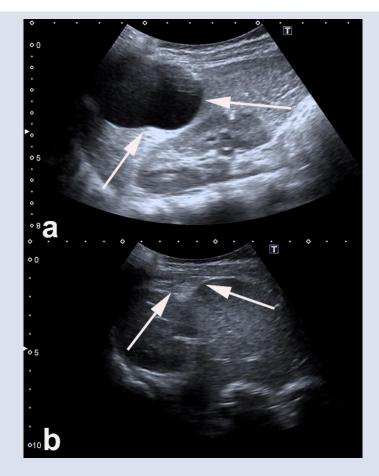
Ultrasound images, (a) pretreatment image shows cystic lesion (arrows) with thin hyperechoic wall, and (b) post-treatment image shows after complete aspirated of diaphragmatic mesothelial cyst (arrows).
